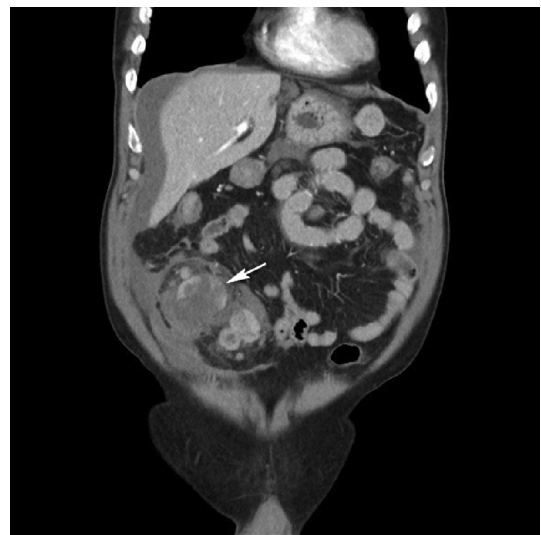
Contrast-enhanced computed tomography scan of abdomen demonstrating a ruptured peritoneal seeding HCC tumor (white arrow) in the right lower quadrant of the abdomen, accompanied by hemoperitoneum.
